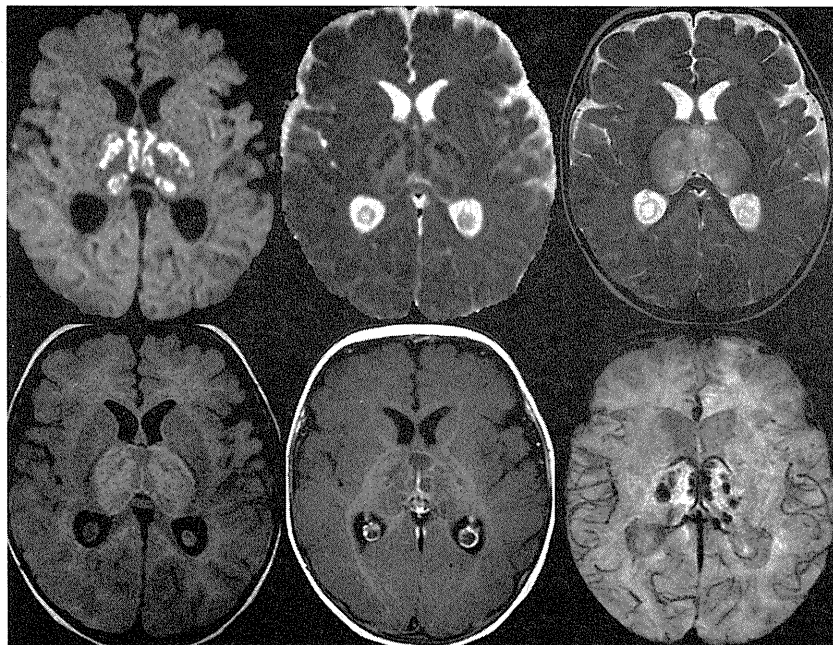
MRI at presentation. (A) Axial diffusion-weighted image; (B) Axial ADC map; (C) Axial T2-weighted image; (D) Axial FLAIR image; (E) Contrast-enhanced axial T1-weighted image; (F) Axial susceptibility-weighted image. Diffusion-weighted images (A) and corresponding ADC map (B) clearly show multiple areas of restricted diffusion against a background of increased diffusion involving both thalami, which are swollen. On T2-weighted (C) and FLAIR (D) images, the thalami are markedly swollen and hyperintense. On T1-weighted images obtained after intravenous gadolinium chelate injection (E), multiple necrotic portions are well delineated by peripheral faint, linear enhancement. Incidental choroid plexus cysts are detected. Susceptibility-weighted image (F) shows multiple hypointense spots, consistent with petechial hemorrhage.
